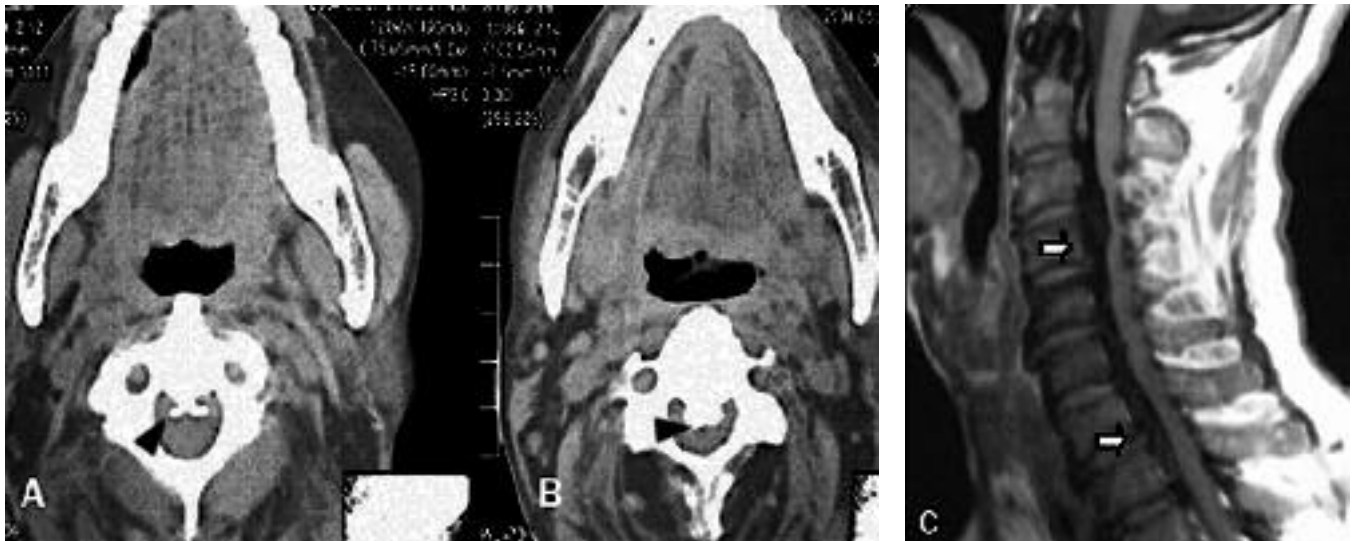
Ossified ligaments of the cervical spine in fluorosis. A and B: Axial computed tomography shows ossification of the posterior longitudinal ligament causing narrowing of the spinal canal (black arrowheads). C: T1-weighted demonstrates spinal cord compression (white arrows).
